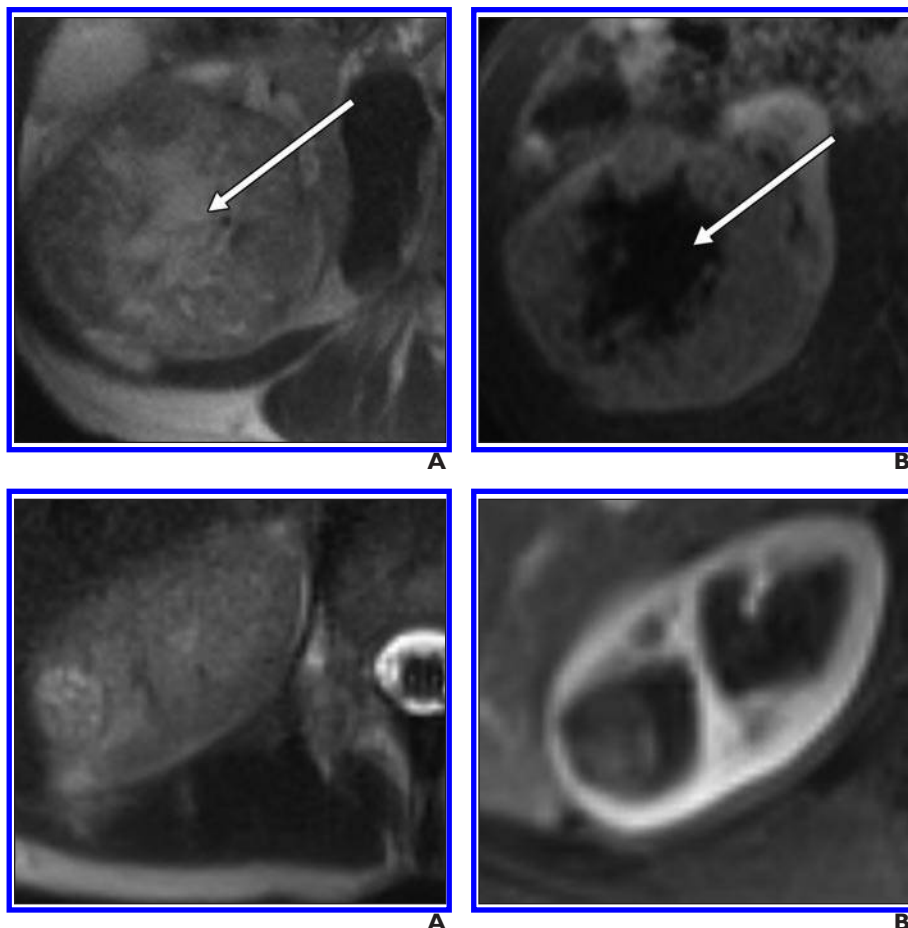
81-year-old woman with pathologically proved chromophobe renal cell carcinoma. A and B, Axial HASTE (A) and axial excretory phase 3D gradient-echo T1-weighted (B) MR images show predominantly well-circumscribed mass with large central scar (arrow) and peripheral heterogeneous solid component that is hypointense relative to renal cortex in B.
